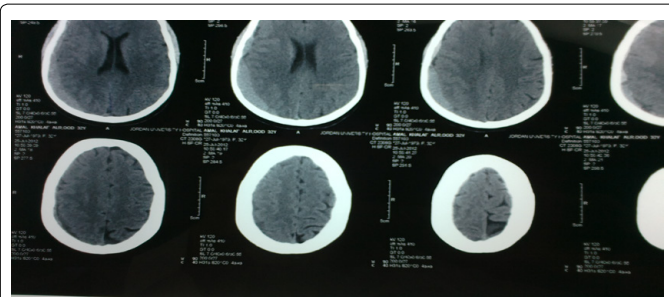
Computed tomography (CT) of the head showing acute subdural hematoma involving the right cerebral hemisphere convexity measuring 15 mm in maximal width and causing mass effect into the underlying right hemisphere sulci.
